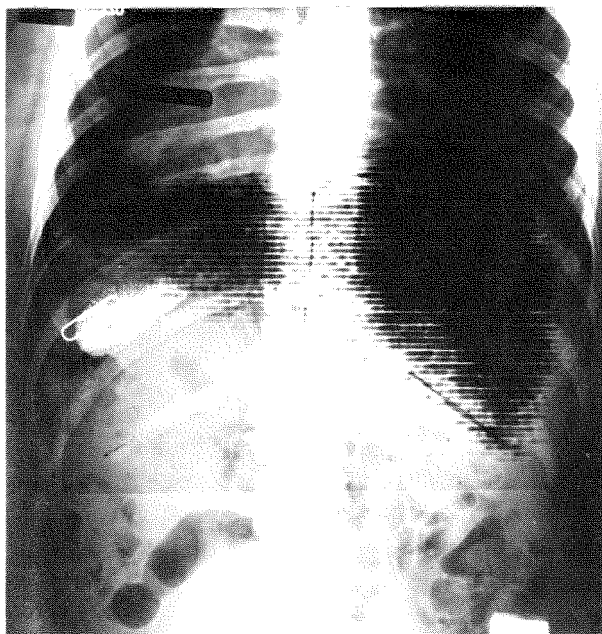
Posterior scan superimposed on radiograph of Case 1. No ^{99m}Tc activity can be seen in region corresponding to thorotrast-filled spleen. Paper clip is $1\frac{1}{2}$ in. long.
